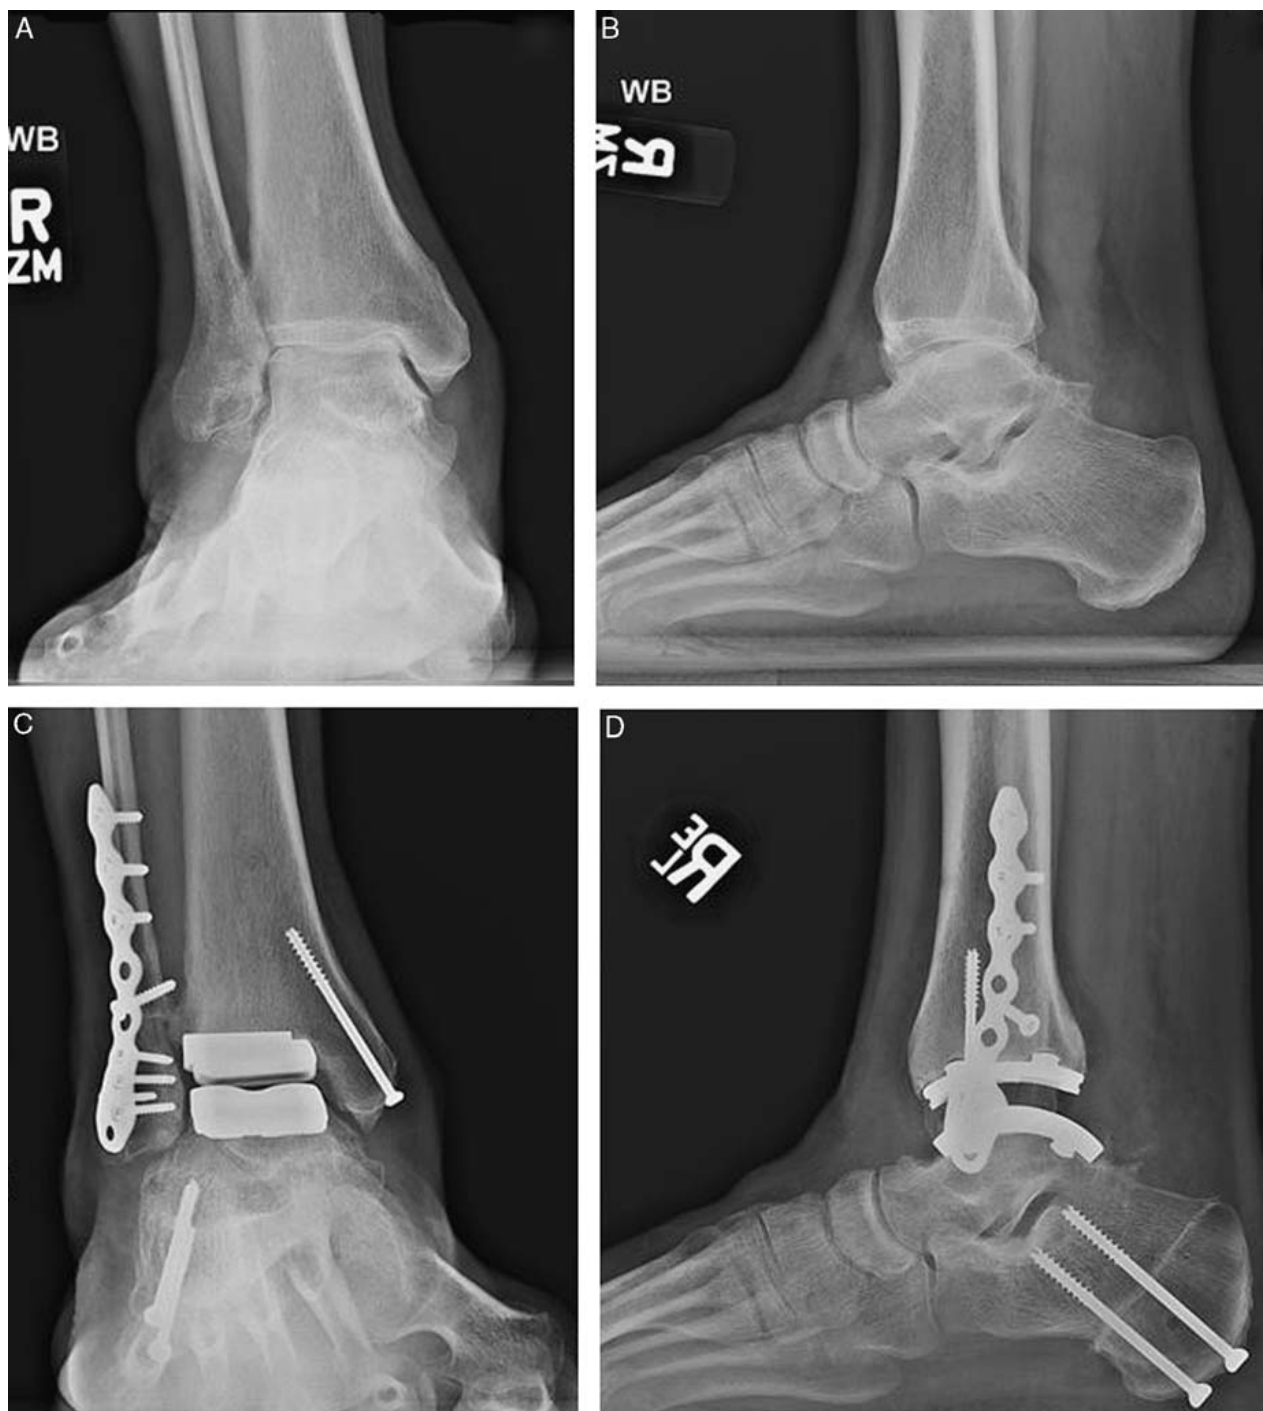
A, Lateral and (B) Mortise radiograph of an arthritic ankle with a significant valgus deformity. Immediate postoperative lateral (C) and mortise (D) images showing correction of the valgus deformity. With significant valgus deformities, the fibula may need to be lengthened through the oblique osteotomy.
